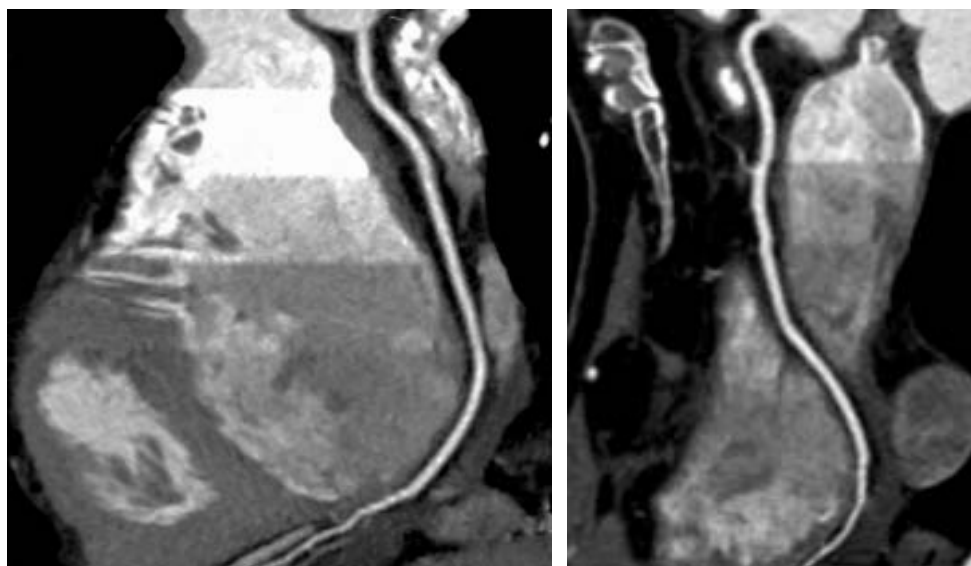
Contrast-enhanced cardiac CT-angiography in a 62 year-old male patient. The curved multiplanar reformations of the right coronary artery do not show any sign of coronary stenosis.
